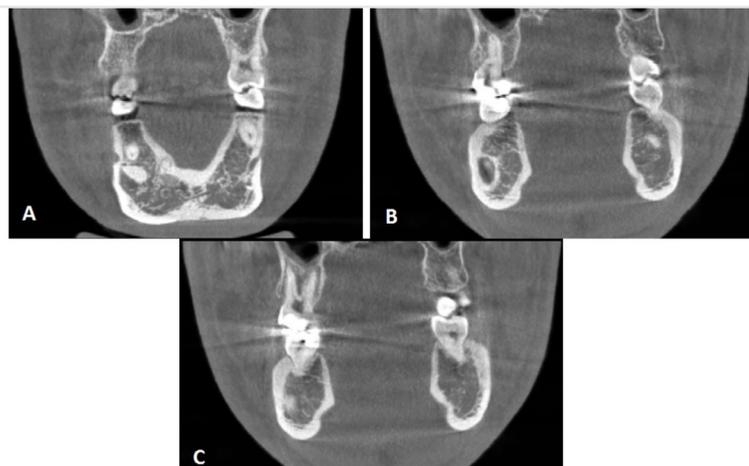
Images of anterior (A), medial (B), and posterior (C) sinus mucosa obtained from CBCT coronal sections
